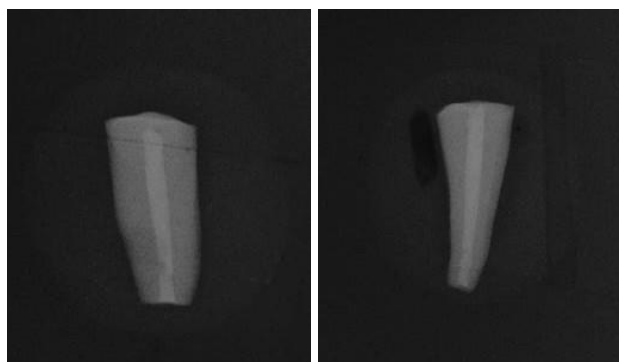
Sample X-ray images after retrograde filling.
